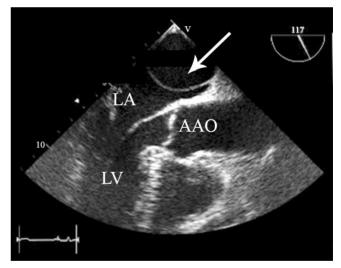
In transesophageal echocardiography, mid-transesophageal aortic valve long-axis view demonstrates an abnormal membrane across the patient's left atrium (arrow)
